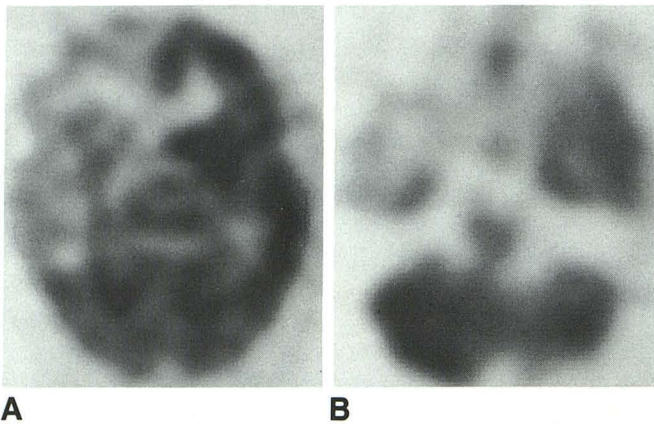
Tc-99m HMPAO SPECT images obtained after temporary balloon occlusion of the right internal carotid artery.
